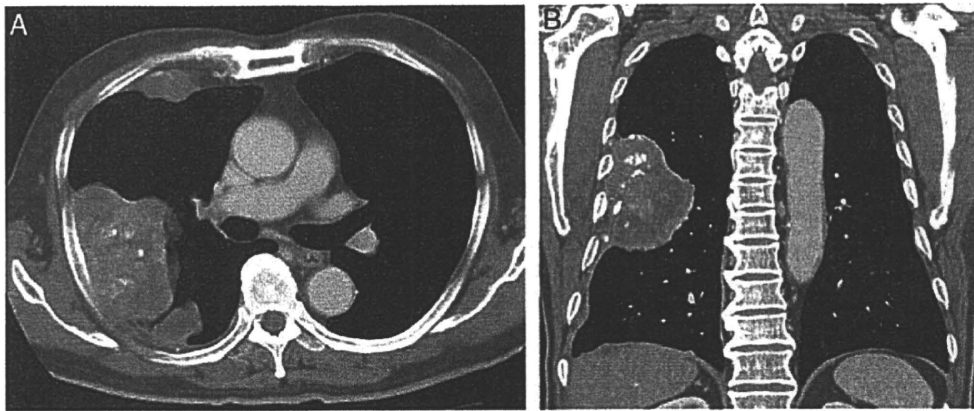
A, Axial contrast-enhanced CT scan of the thorax showing masses in the right pleura. Punctate calcifications were detected in the main tumor. B, Coronal reformatted image clearly shows that the tumor arises from the pleura.
